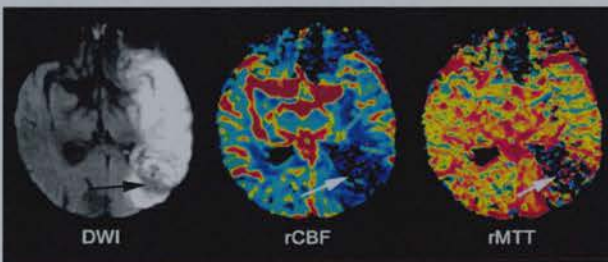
A patient with a smaller PI lesion than DWI lesion
